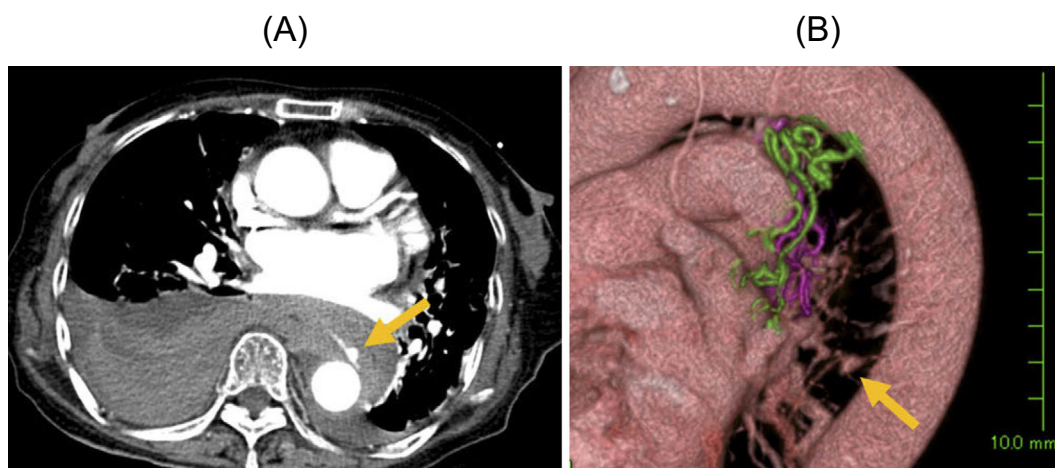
An enhanced computed tomography scan shows a mediastinal hematoma and bilateral hemothorax, especially on the right side (A). A bronchial artery aneurysm (arrow) is present near the descending aorta as shown by an enhanced computed tomography scan (A) and (B) by three-dimensional reconstruction of the enhanced computed tomography scan.
